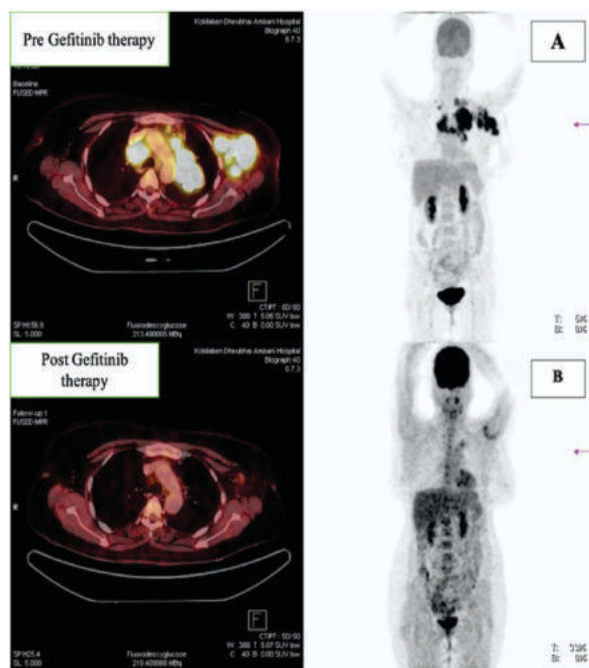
The post gefitinib therapy PET-CT after 3 months (Figure 1B) showed reduction in size of lesion at the primary site along with complete resolution of the metabolic activity at the primary site and lymph node in comparison to the pre therapy PET-CT (Figure 1A).
